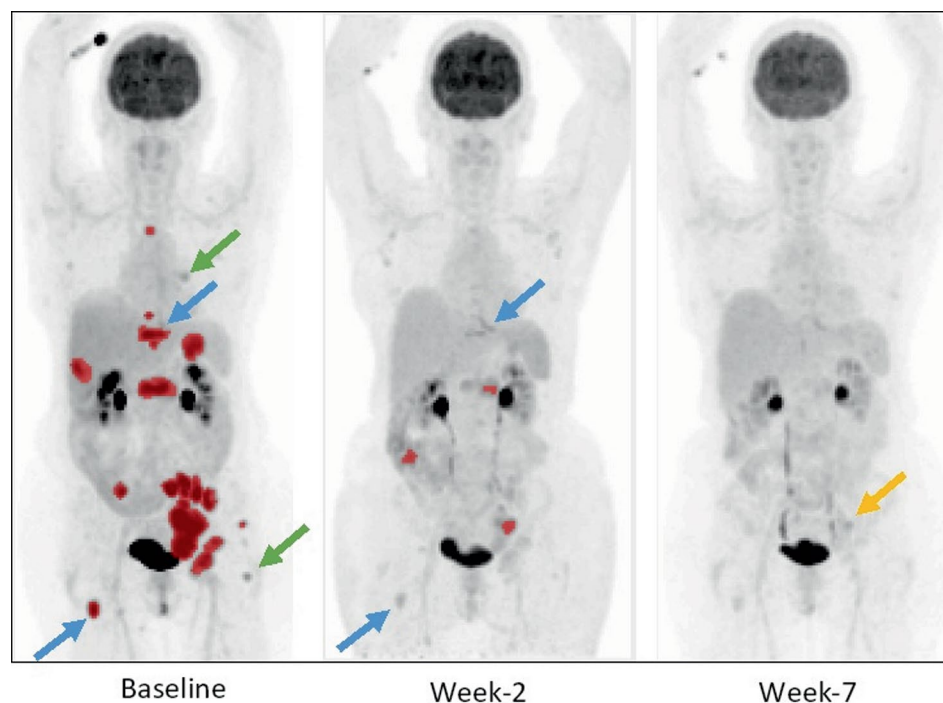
Anterior Maximum Intensity Projections with semi-automatic delineation of target lesions. Maximum Intensity Projection [^{18}F]FDG PET of a patient at baseline, week-2 and week-7. Delineation of melanoma metastases with a $\text{SUV} > 4$ and volume $> 1\text{mL}$ are shown in red. At baseline, some metastases were below the threshold for delineation with Accurate (green arrows; left hilar and left femur). Blue arrows demonstrate metastases that were delineated at baseline, but were below the threshold at week-2, though still visible. At week-7, minimal residual tumor was present (orange arrow), but no metastases could be delineated and the scan was therefore classified as not quantifiable
